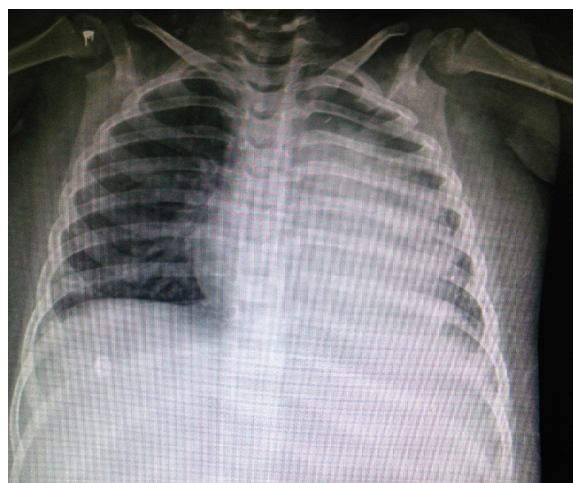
Chest X-ray showed an enlarged cardiac silhouette, consolidation in the inferior lobe of left lung and pleural effusion.
